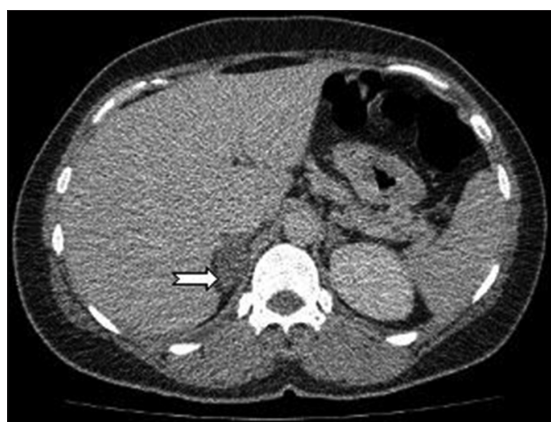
In axial contracted CT section in the right adrenal gland hypodense nodular lesion (white arrow) can be seen size in diameter 32 × 20 mm
